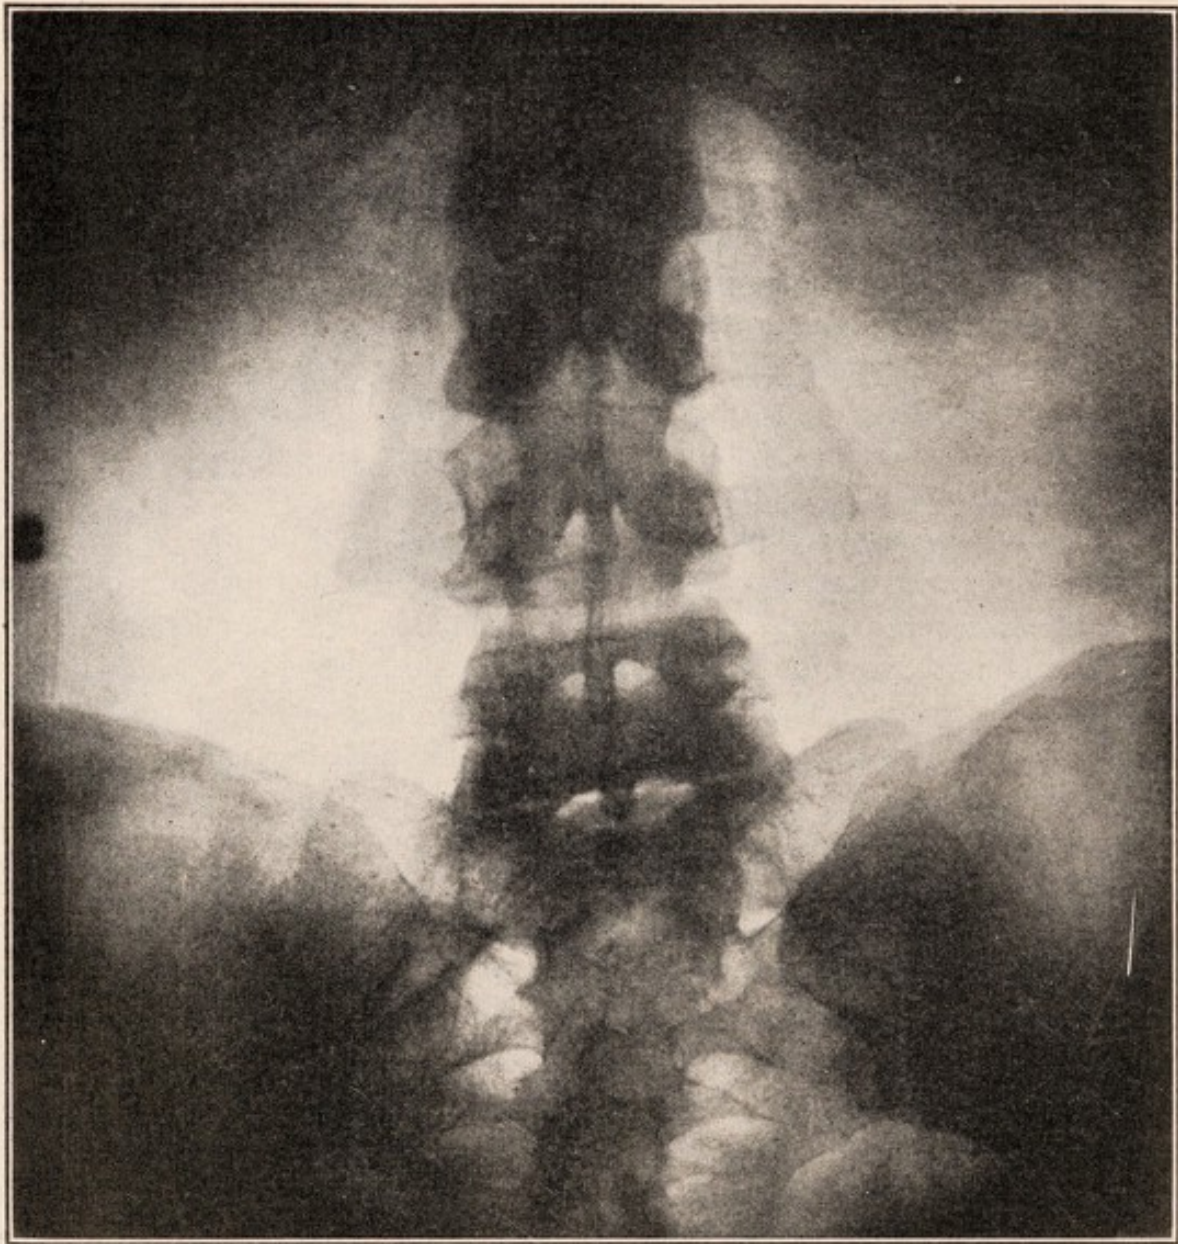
Sacralization of the fifth lumbar vertebra. (*Courtesy of Doctor J. F. Lutz from the X-ray laboratory of the Hebrew Hospital.*)
